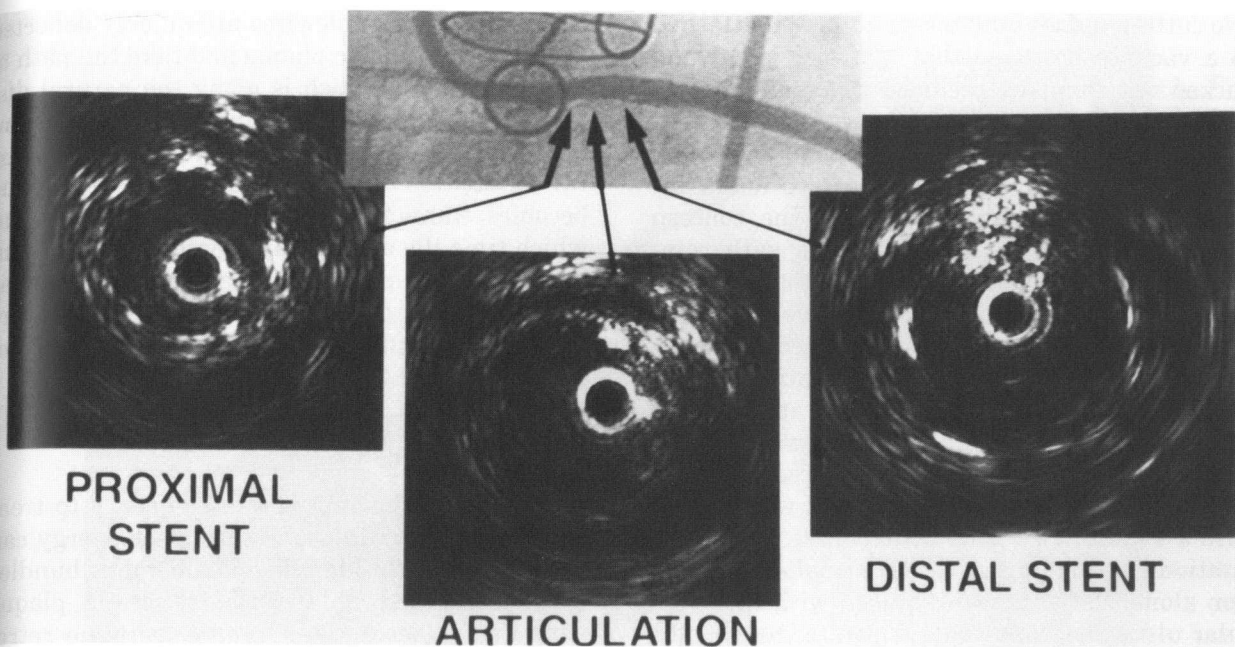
Post balloon angioplasty. A successful stent deployment imaged by IVUS. The echogenic metallic struts of the stent are fully apposed to the atherosclerotic plaque. However, the lumen area is still small, and a larger balloon size could be used based on the ultrasonic image guidance.
